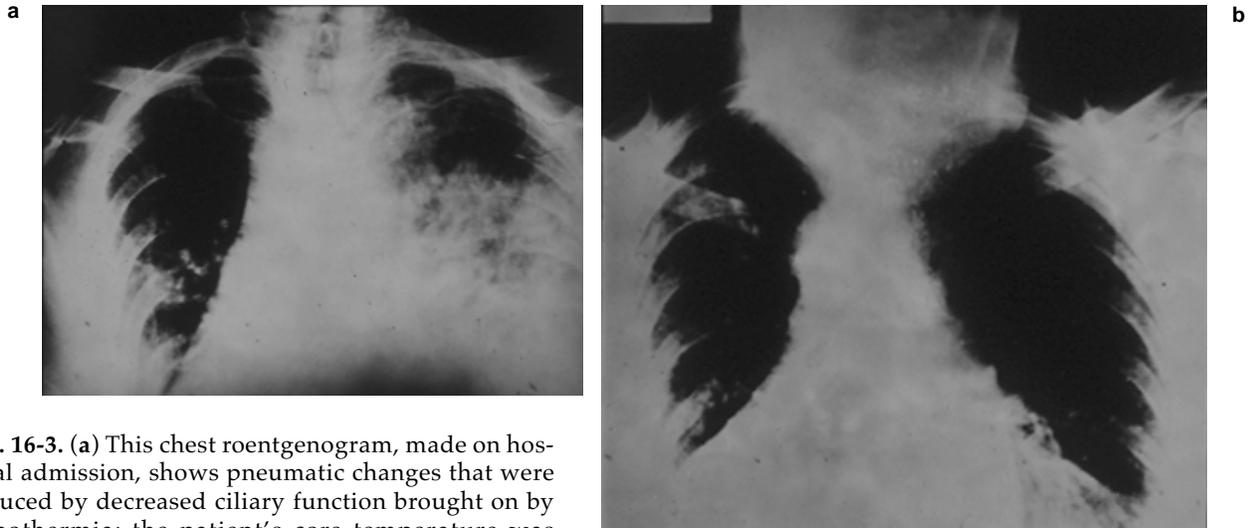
(a) This chest roentgenogram, made on hospital admission, shows pneumatic changes that were induced by decreased ciliary function brought on by hypothermia; the patient's core temperature was 32.5°C. (b) This chest roentgenogram of the same patient shows marked improvement on reaching normothermia after 12 hours of airway warming treatment. The pneumonia-like pulmonary changes resolved purely with re-warming. taken together, these roentgenograms demonstrate the important point that clinical management decisions should not be taken while the patient is hypothermic. Reprinted with permission from Lloyd EL. *Hypothermia and Cold Stress*. Hampshire, England: Chapman & Hall; 1986:53.
